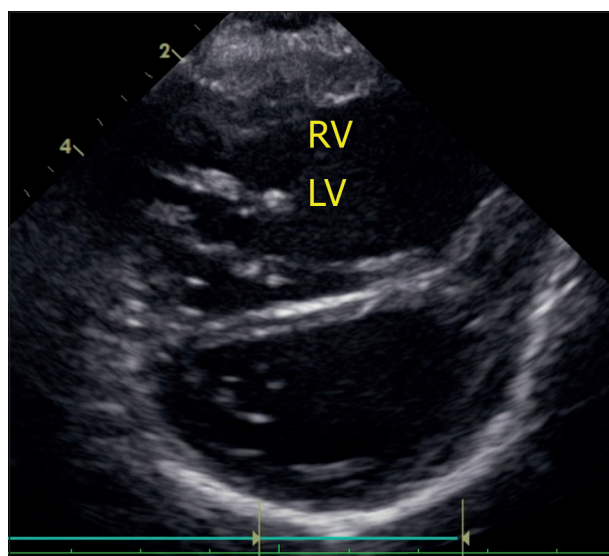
Echocardiogram image in short-axis view at the level of the ventricles showing the late evolution after the second pulmonary artery band during the retraining period (Age 4 years). The image shows the rectification of the septum, left ventricle (LV) on the lower wall of the image and right ventricle (RV) on the upper wall.
